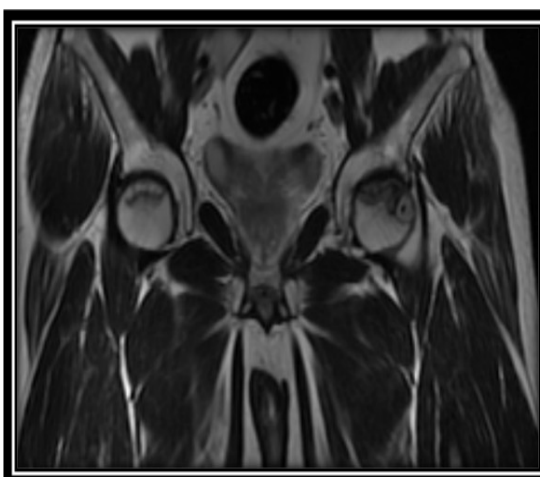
(A-E):A male patient aged 60 years with bilateral avascular necrosis of femoral head stage 2 on the right side and stage 3 on the left side. (A)Plain X-ray of both hips (A.P.V.) revealed; Relative subchondral sclerosis of femoral heads on both sides(yellow arrows).(B, C & D) MR T1WI, MR T2WI coronal sections & MR T2WI coronal section with fat suppression of both hips revealed: On the right side there is low signal intensity of subchondral region in both T1 & T2. On the left side there is loss of normal roundedness of femoral head indicating collapse, bone marrow edema of femoral head, intertrochanteric region and neck appears hypointense in T1 & hyperintense in T2 & STIR images, with osteophytic formation and joint effusion. (E) MR T2WI (axial section) of both hips revealed: serpiginous hyperintense area at the right femoral head showing "double line sign"(white arrow) & joint effusion at the left hip.
